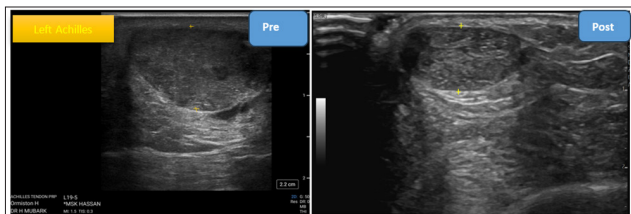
Pre- and post-PRP Ultrasound Demonstrating Reduced Left Mid-Portion Achilles Tendon Thickness with Resolution of Hyperaemia.
